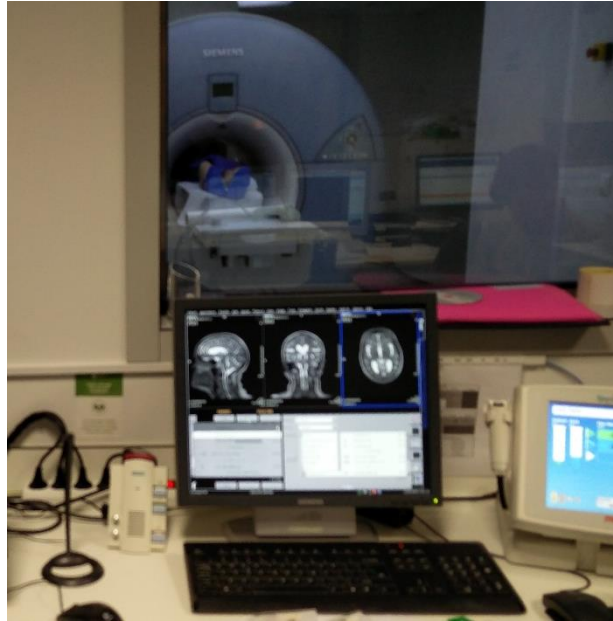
Host computer of the MRI system at Hospital de Braga.
